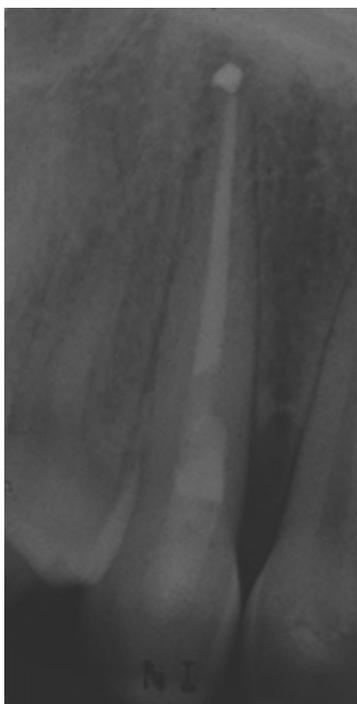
Periapical radiograph after 3-month showing the initial healing of periapical lesion and the essence of parodontal defect.
